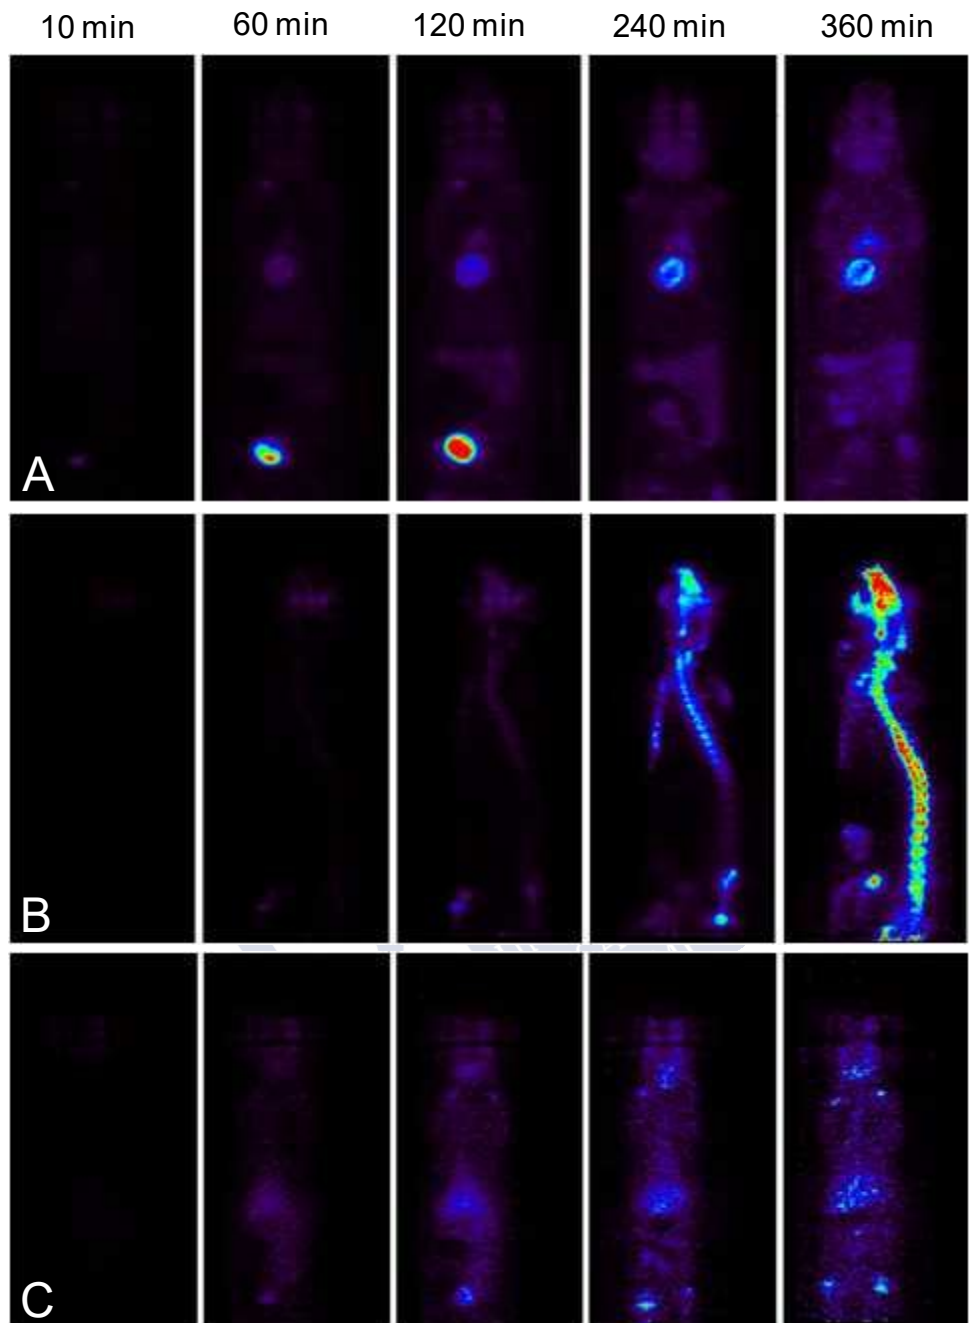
Representation of the systemic distribution of radiotracers at different times after intravitreal administration. A) Coronal views after injection of ^{18}F -FDG. B) Sagittal views after injection of ^{18}F -NaF. C) Coronal views after injection of ^{18}F -Choline.
